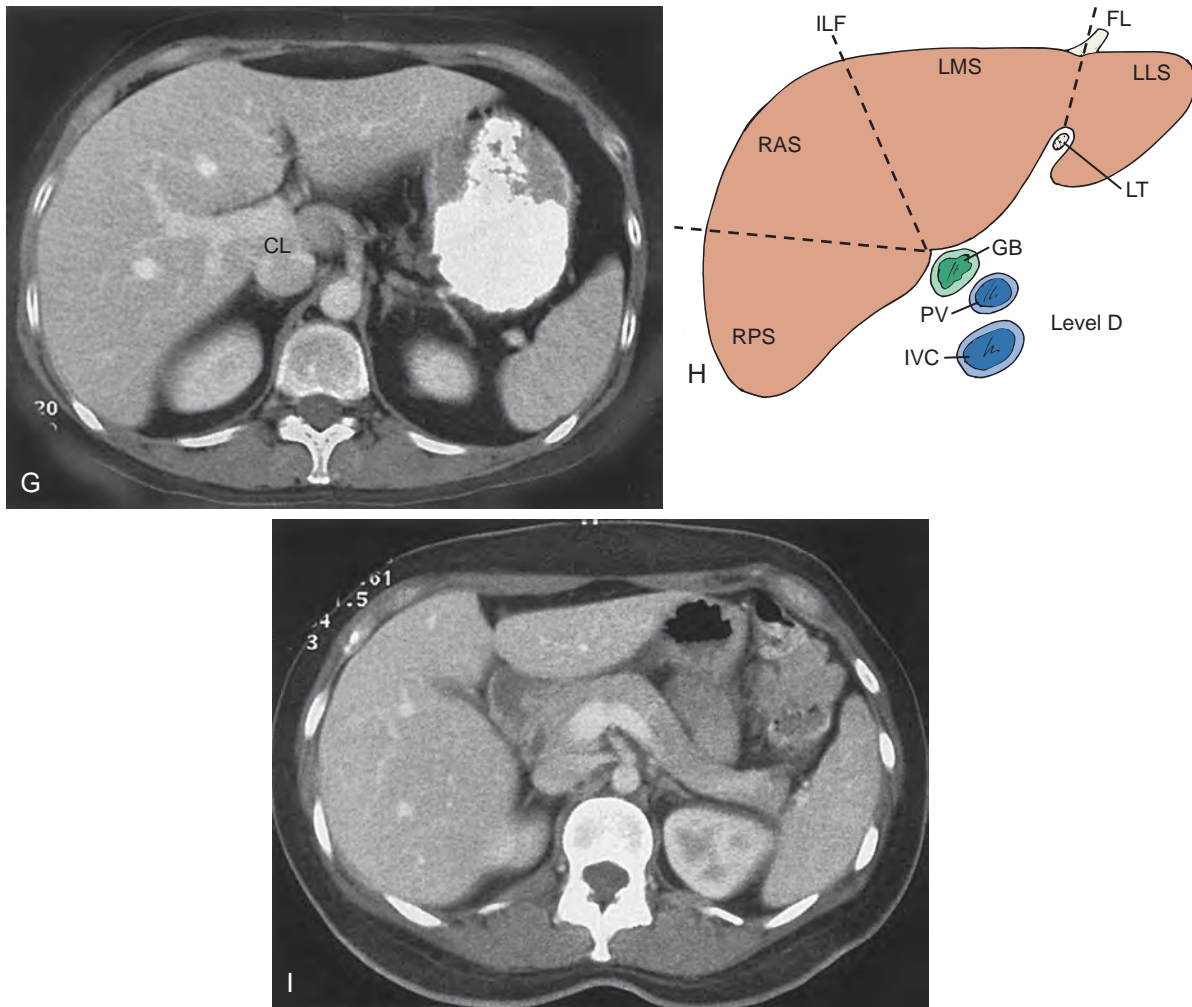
cont'd G. Corresponding CT section. H. Axial anatomy, level D. The right and left hepatic lobes are separated by a line drawn through the IVC and the gallbladder fossa–interlobar fissure (ILF). This fissure extends superiorly from the neck of the gallbladder and is often incompletely visualized on CT. The LLS and LMS are separated by the LT. I. Corresponding CT scan.
